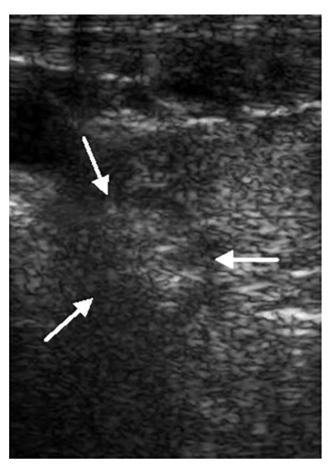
Ultrasound shows a gradual and diffuse increase in echogenicity of the mass from the irradiating segment to the whole mass during microwave ablation (arrows).
